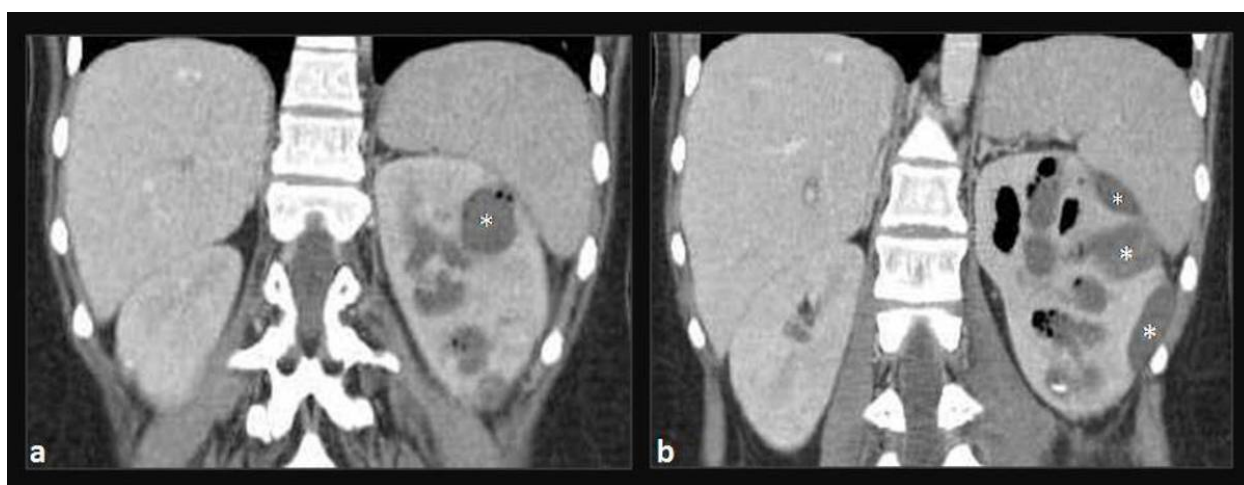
Emphysematous pyelonephritis (same case as in figs. 16 and 17). Coronal contrast-enhanced CT images show multiple air bubbles within both the renal parenchyma and the collecting system, with associated fluid collections (*).
